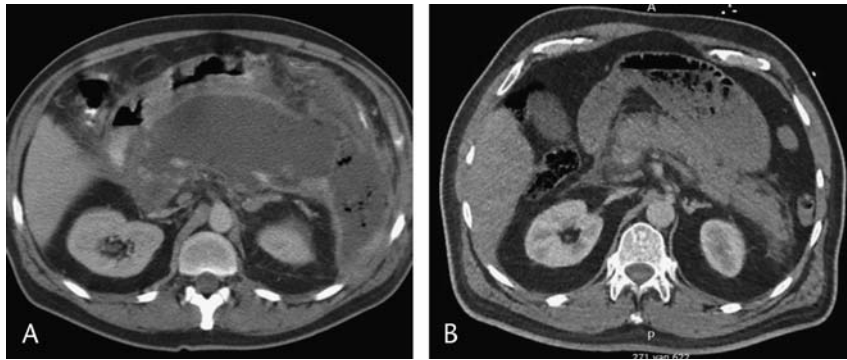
Two of the 55 CTs reviewed in this interobserver agreement study. A, Most of the reviewers described this CT as >50% pancreatic nonenhancement with a collection that is intrapancreatic and adjacent to the pancreas, which is partially encapsulated, heterogeneous, with mass effect, irregular shaped, with loculated gas bubbles, and without a gas-fluid level. All reviewers defined the type of pancreatitis as necrotizing pancreatitis. The CT was obtained 21 days after onset of disease. Most of the reviewers defined this as necrotizing pancreatitis with a collection defined as an acute necrotic collection. B, Most of the reviewers described this CT as >50% pancreatic nonenhancement with a collection that is adjacent to the pancreas, which has no encapsulation, heterogenous, no mass effect, irregular shaped, with no loculated gas bubbles, and without a gas-fluid level. The CT was obtained at day 10 after onset of disease. Most of the reviewers defined the type of pancreatitis as necrotizing pancreatitis with an acute necrotic collection.
